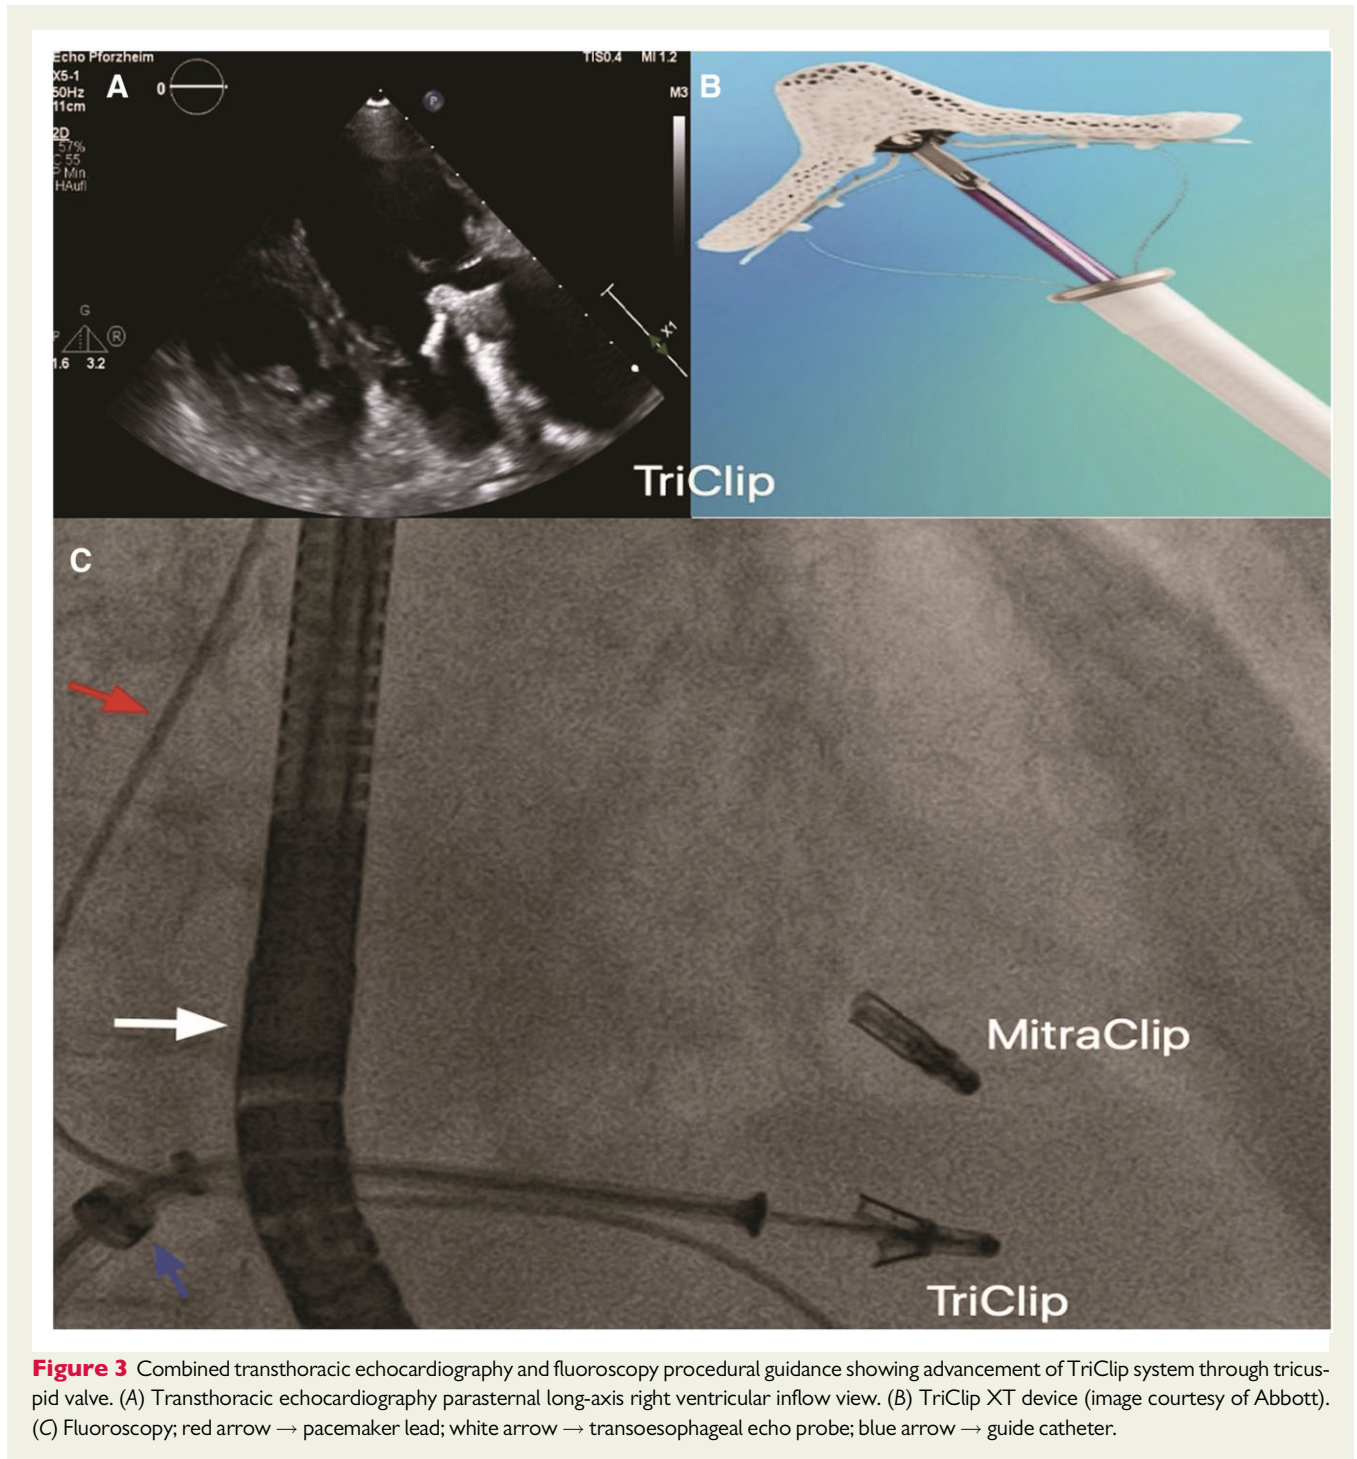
Combined transthoracic echocardiography and fluoroscopy procedural guidance showing advancement of TriClip system through tricuspid valve. (A) Transthoracic echocardiography parasternal long-axis right ventricular inflow view. (B) TriClip XT device (image courtesy of Abbott). (C) Fluoroscopy; red arrow → pacemaker lead; white arrow → transoesophageal echo probe; blue arrow → guide catheter.
